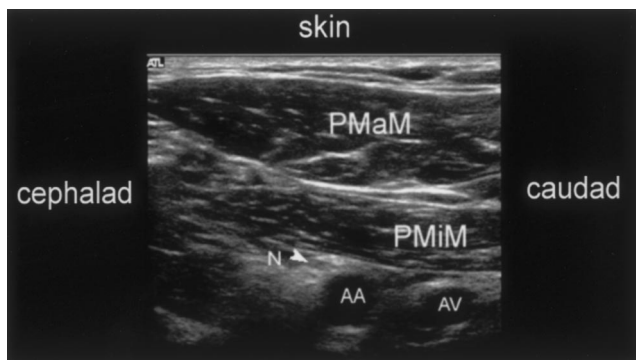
Transverse sonogram in the infraclavicular region showing brachial plexus as hypoechoic nodules (*N* with arrow). AA = axillary artery; AV = axillary vein; PMaM = pectoralis major muscle; PMiM = pectoralis minor muscle.
